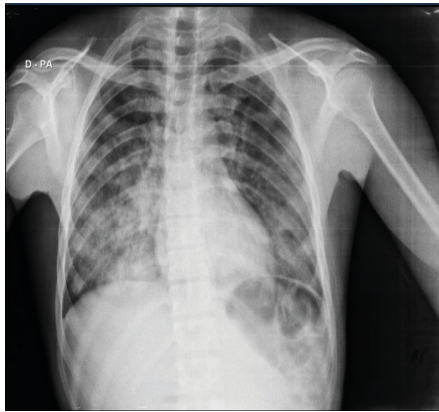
Chest X-ray on admission: bilateral heterogeneous and irregular infiltrates, more significant on the right. (source: own author)
